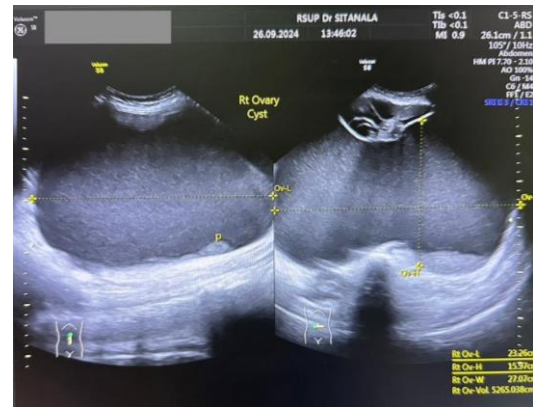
Transabdominal Ultrasound showed a uterus with normal shape and size impression; there was a mixed echogenic picture in the adnexa with a size of 23.2 cm x 15.9cm x 27 cm with a volume of 5265 cc
